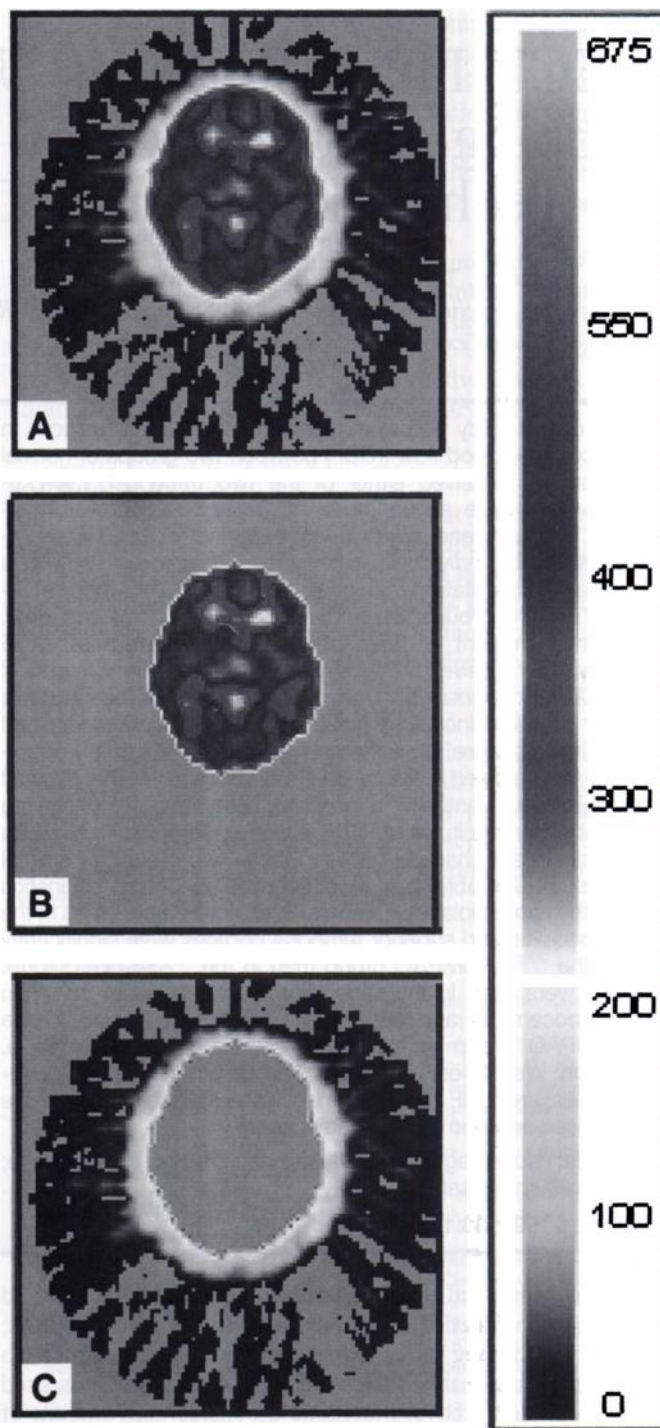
Example of SPECT image slice, pre- and post-thresholding. (A) Image slice after smoothing 6 mm but before thresholding. (B) Post-thresholding. (C) Subtracted image (A - B = C). This level of thresholding removes halo and partial volume error as much as possible while preserving brain signal.
